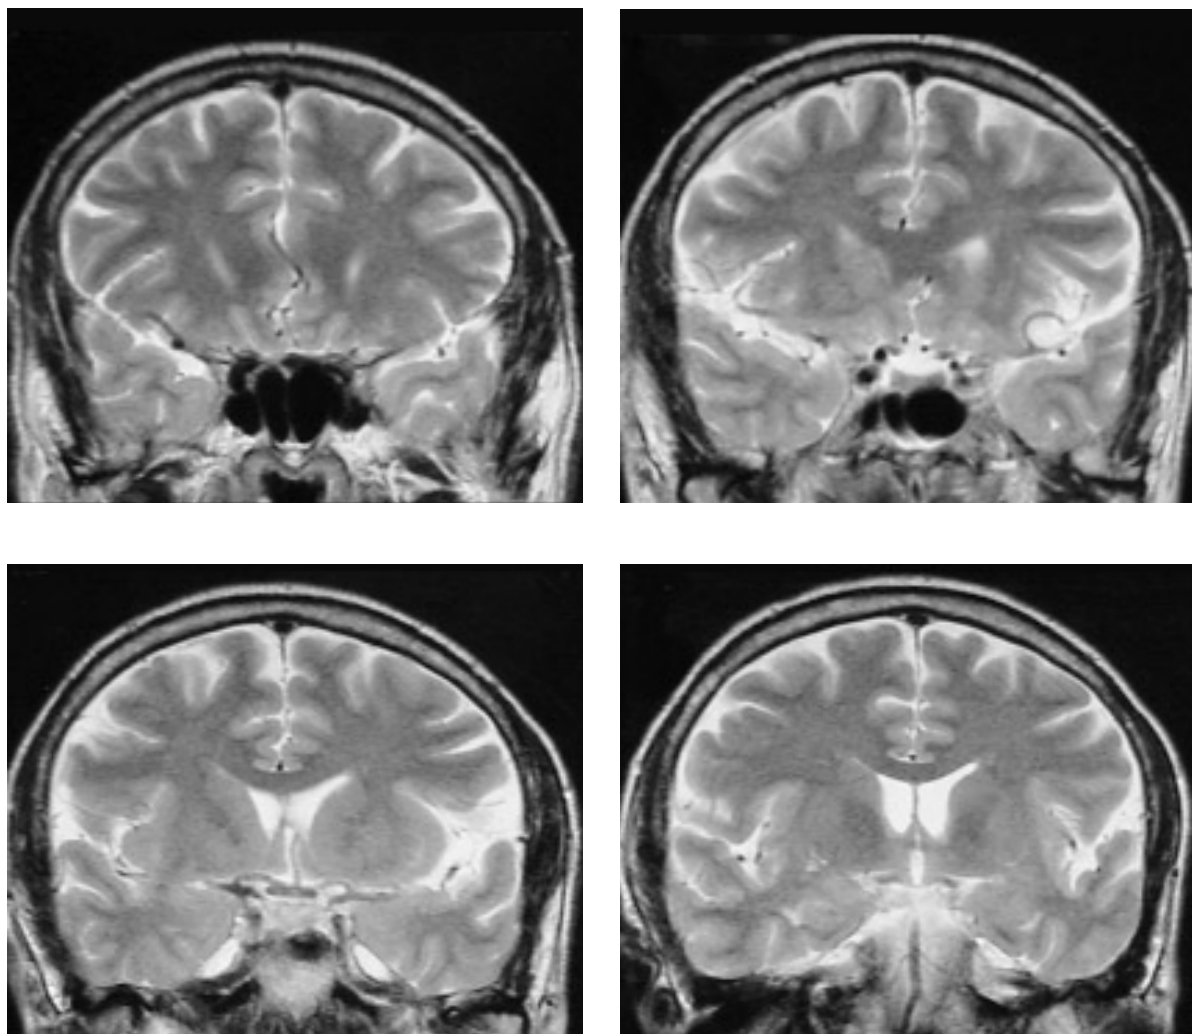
Pre-stenting cranial MRI: Transverse FLAIR (A) and T2 coronal (B) subsequent images do not show any evidence of arteriovenous malformation.
